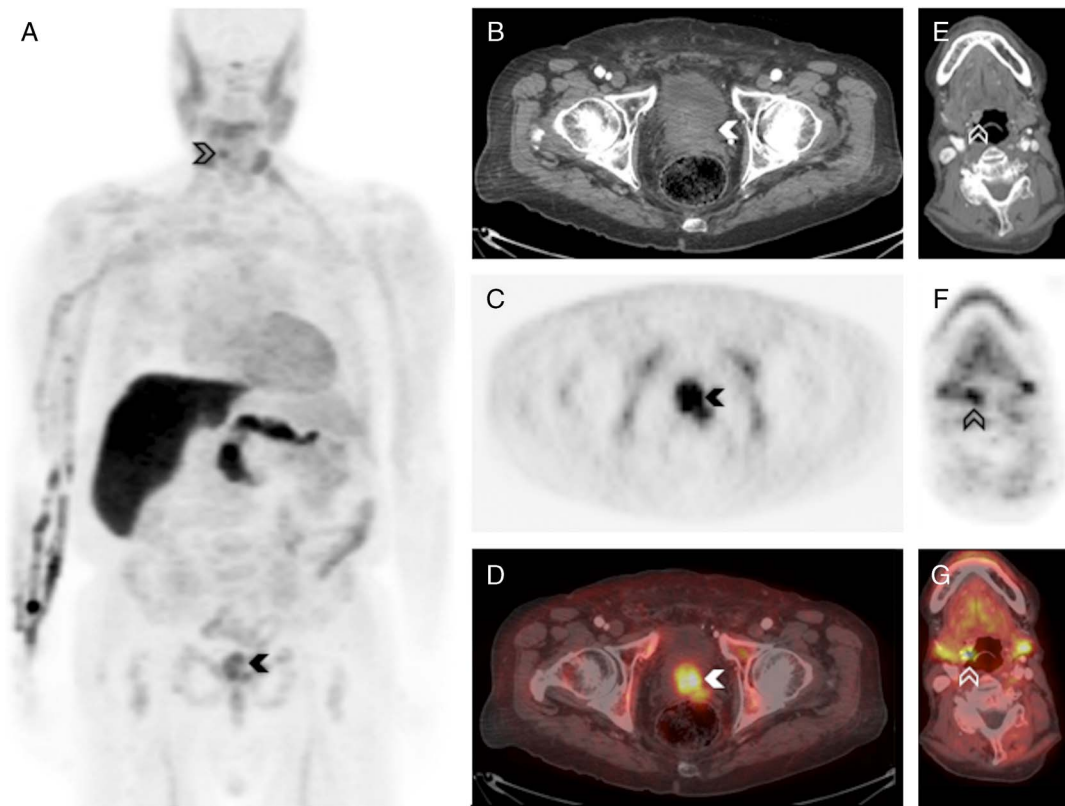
A 79-year-old man with history of locally advanced prostate carcinoma (Gleason score 4 + 5 = 9; cT2cN1M0) initially responsive to androgen deprivation therapy (luprolide + bicalutamide) presented with slowly rising serum prostate-specific antigen from 0.9 to 2.5 ng/mL over 3 years, concerning for recurrent disease. To identify potential sites of recurrence, an ^{18}F -fluciclovine PET/CT was performed with PET images acquired 4 minutes after injection of 10.7 mCi (395.9 MBq). MIP PET (A) images demonstrated focal radiotracer uptake in the prostate gland (solid arrowhead). CT (B), PET (C), and transaxial fused PET/CT (D) identified ill-defined, tracer-avid soft tissue in the left aspect of prostate gland with possible seminal vesicle involvement, compatible with prostate cancer without nodal or osseous radiotracer-avid metastases. However, a fluciclovine-avid lesion was noted in the right oropharynx (open arrowhead) on MIP PET (A), corresponding to an enhancing exophytic 1.1-cm right tongue base mass on CT (E), PET (F; SUVmax 5.6, uptake greater than bone marrow), and fused PET/CT (G). Because prostate cancer metastasis to the oropharyngeal mucosa is rare,¹ the possibility of a second primary malignancy was raised.
